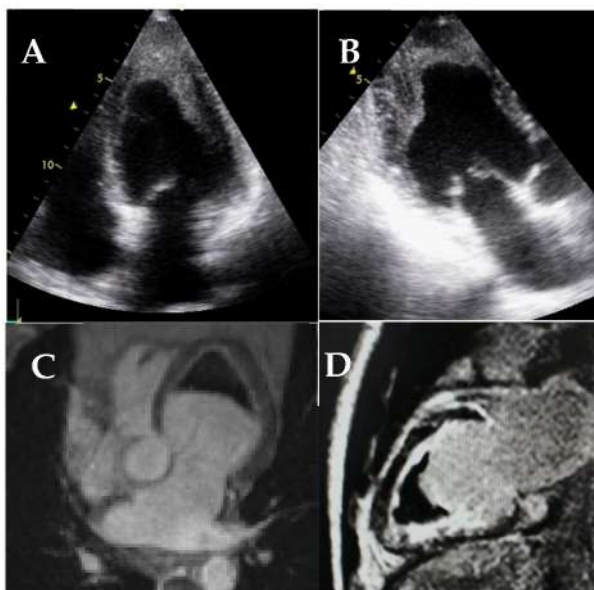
Transthoracic echocardiography (A,B) and cardiac magnetic resonance (C,D) of patients with endomyocardial fibrosis. Note the marked endocardial thickening of the mid and apical segments and apical obliteration of the left ventricle (A,B), the apical thrombus (C,D), and the endomyocardial fibrosis on LGE sequences (D).
